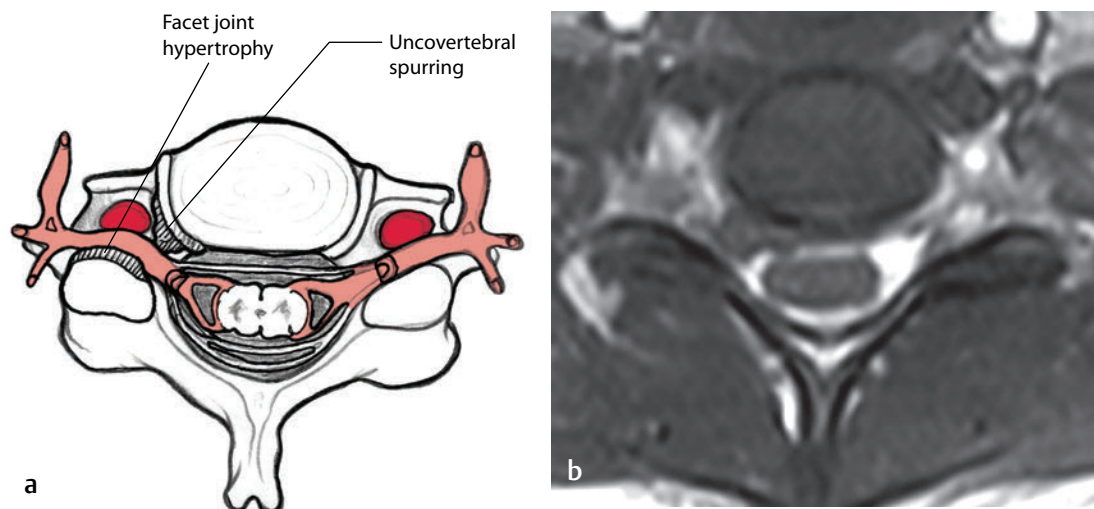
This (a) artist's sketch shows cervical foraminal stenosis and nerve root impingement from facet joint hypertrophy and uncovertebral spurring resulting in cervical nerve root compression.[†] (b) An axial T2-weighted image shows cervical foraminal nerve root compression by a right-side disc herniation.
